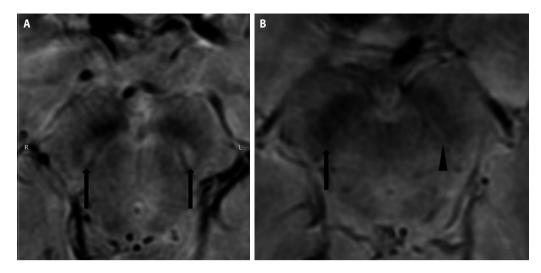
MRI, axial plane, high-resolution SWI. A. Bilateral DNH (arrows) – normal 'swallow-tail' sign, indicating healthy subject; B. Lack of DNH on right (arrow) and small, hardly visible nigrosome-1 on left (arrowhead), indicating PD
